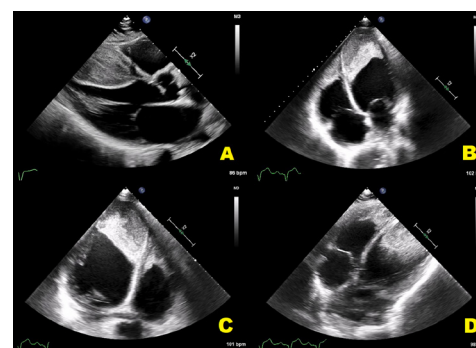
Transthoracic echocardiography without contrast demonstrating large-volume biventricular thrombi. (A) Parasternal long-axis view demonstrating thrombus in the left ventricle; (B) standard four-chamber view demonstrating thrombi in both ventricular apices; (C) off-axis/non-standard four-chamber view demonstrating thrombi in both ventricular apices and (D) subcostal view demonstrating large-volume biventricular thrombi. bpm, beats per minute.
